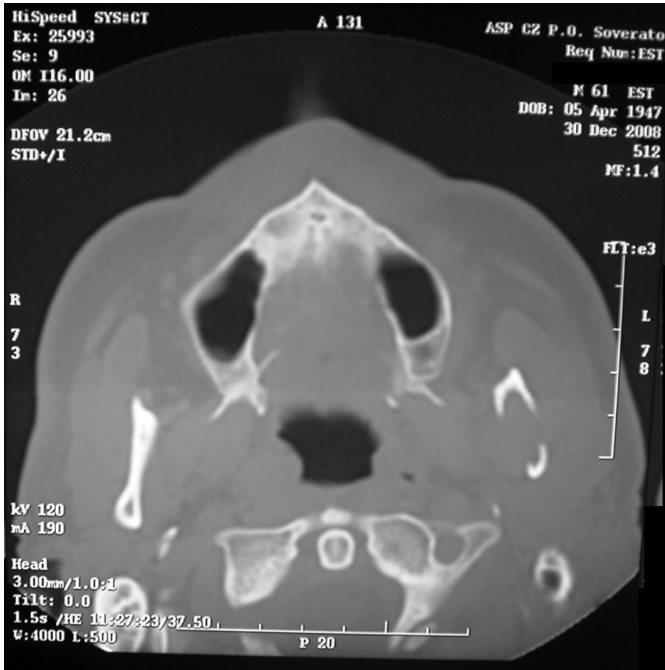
Preoperative CT revealing an osteolytic lesion of ascending branch of the left hemimandible.
